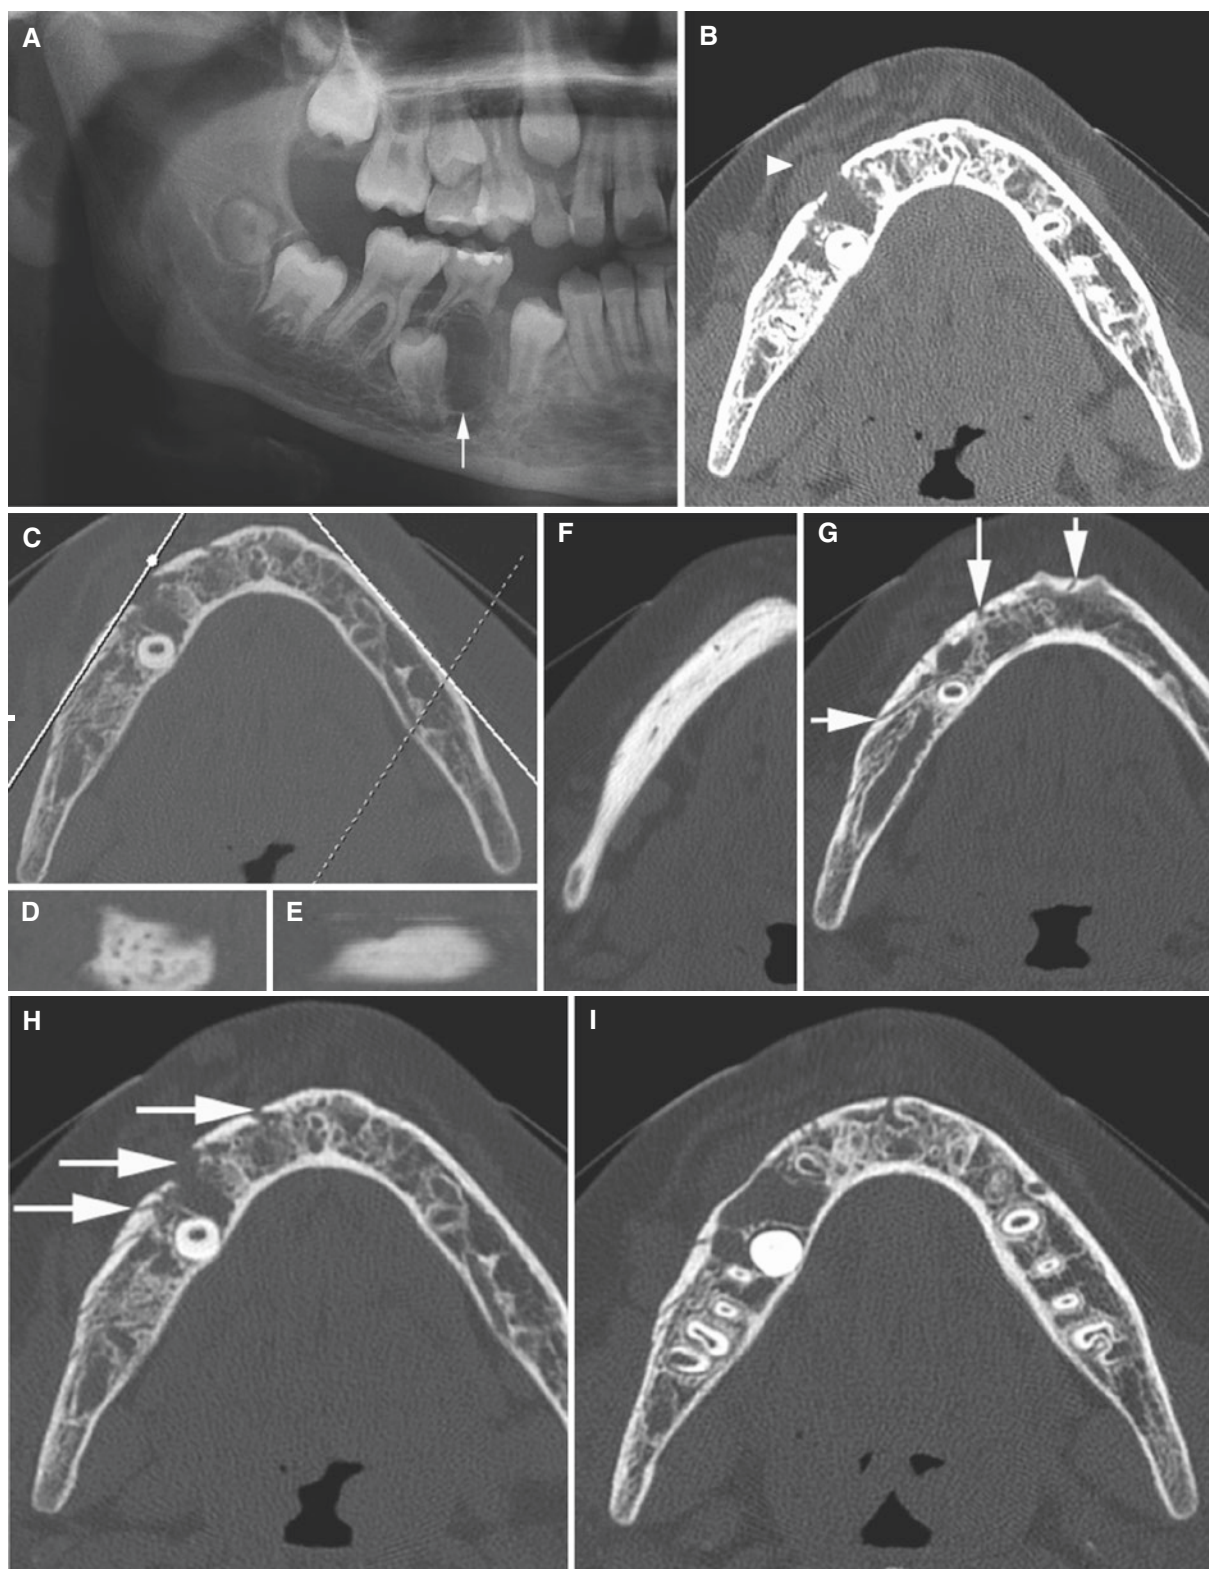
Vascular malformation, mandible; 11-year-old female with some swelling in the right mandible and, from time to time, bleeding from gingiva (see clinical photograph and CBCT images of this patient in Fig. 15.80). (A) Panoramic view shows radiolucency (arrow). (B) Axial (soft-tissue) CT image shows soft-tissue mass (arrowhead). (C) Axial (with cursor lines), (D) oblique sagittal (right), (E) oblique sagittal (left), and (F) axial CT images of the cortical bone show punctate
